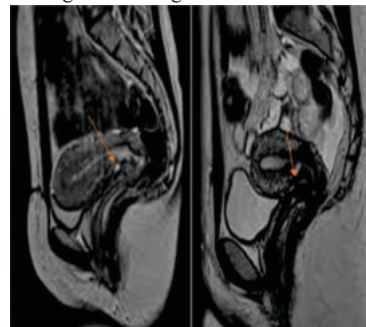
MRI Picture Showing Defect In The Anterior Wall Of Uterus, (orange arrow) Likely Scar Dehiscence.
